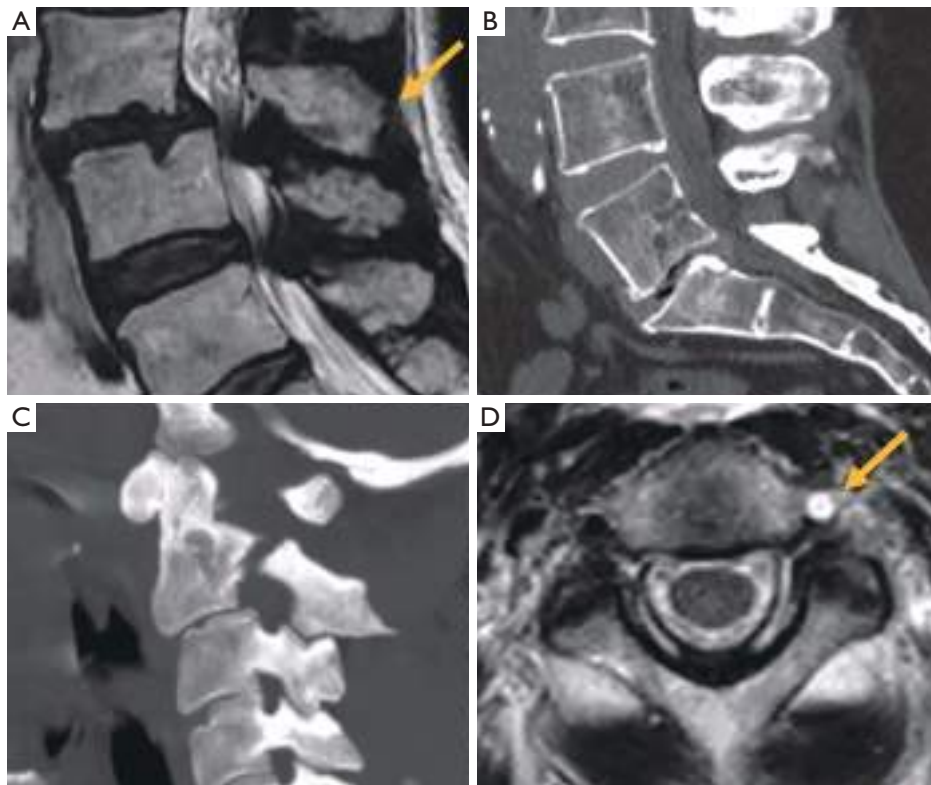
Alignment abnormalities in three patients. (A) Sagittal T2 weighted image of a patient with degenerative spondylolisthesis with narrowing of the central canal and anterior shifting of the spinous process (arrow). (B) Sagittal CT with retrolisthesis of L5. (C) CT with MIP reconstruction in Hangman's fracture. (D) Axial T2 of a hyperintense vertebral artery (arrow) secondary to arterial dissection in Hangman's fracture. CT, computed tomography; MIP, maximum intensity projection.
